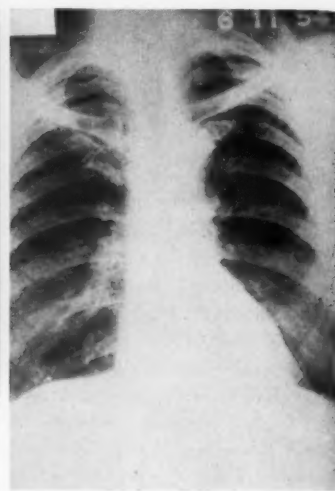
Chest x-ray of 1954 showing rounded area of density in the left 1st interspace. No real change in x-rays of 1956.
